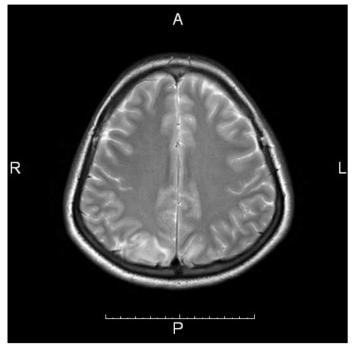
MRI of the brain showing an abnormal signal intensity of white matter involving both parietal-occipital regions that appear hyper-intense
